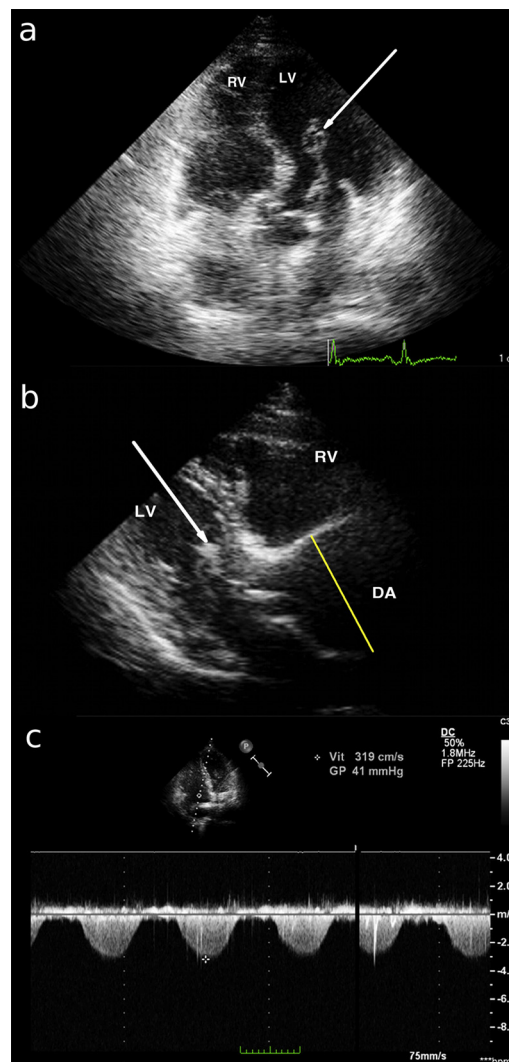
Transthoracic echocardiogram; a: apical view; b: parasternal long-axis view showing dilated right cavities, 70 mm aneurysm of the aortic root and a large serpentine embolus entrapped in the mitral leaflet floating in the left ventricle (white arrow); continuous Doppler of tricuspid regurgitation. RV: right ventricle; LV: left ventricle; DA: dilated aortic root.
